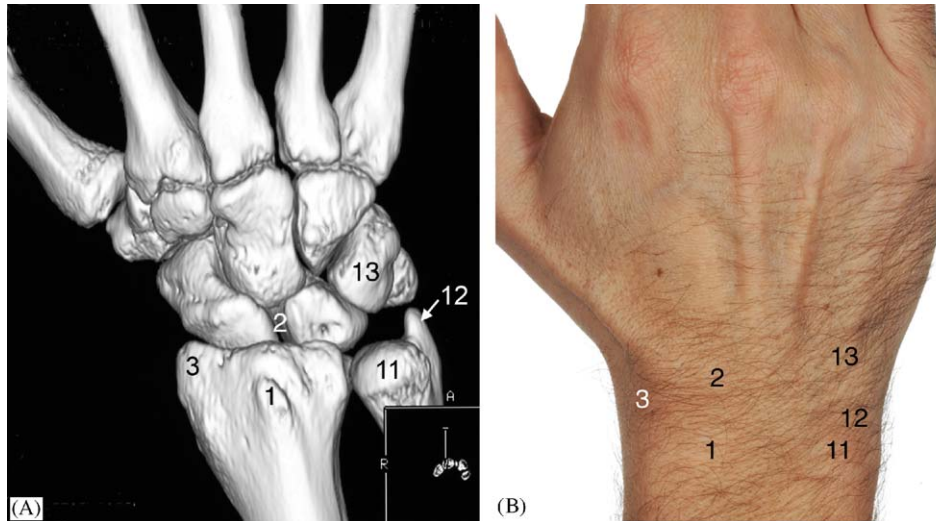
Dorsal view of the carpus and wrist as 3D CT reconstruction (A) and clinical photograph (B). Landmarks in both figures are—(1) Lister's tubercle, (2) crucifixion fossa at the level of the scapholunate junction, (3) radial styloid process, (11) head of ulna, (12) ulnar styloid process, (13) triquetrum.
